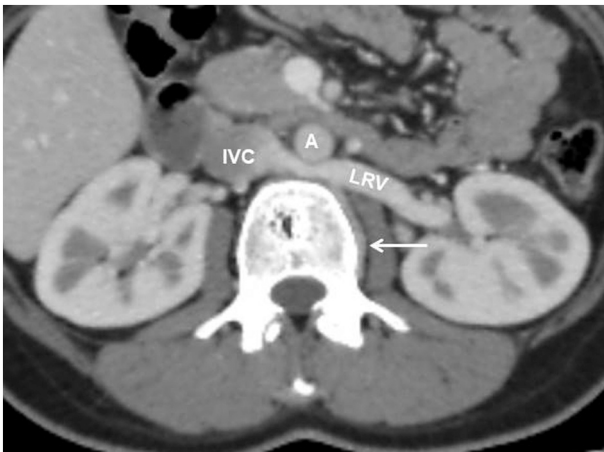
Axial plane contrast-enhanced CT image at L3 vertebra level shows normal anatomy of the ALCV (arrow) in a 32-year-old female patient with retroaortic LRV. A: Abdominal aorta IVC: Inferior vena cava LRV: Left renal vein.
